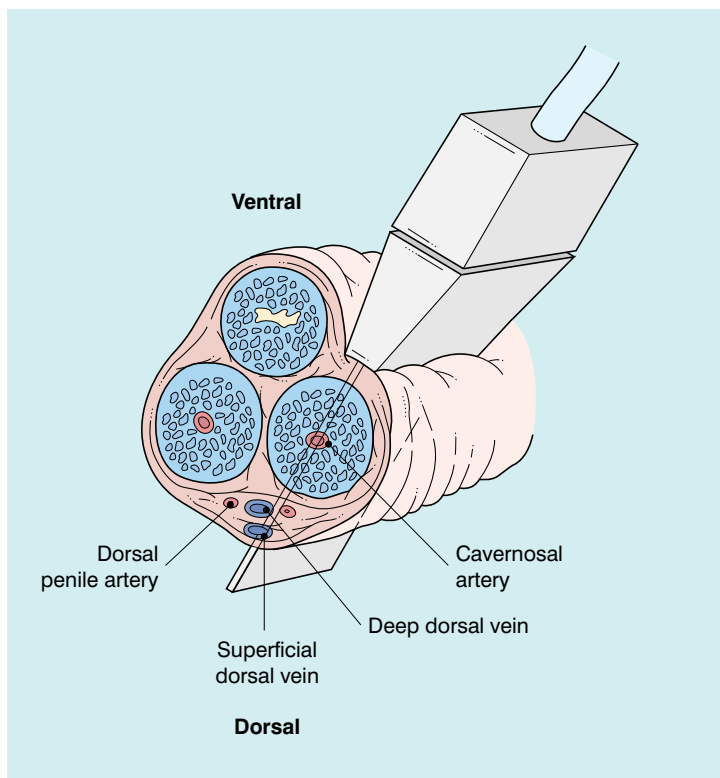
Ultrasound technique. A linear transducer is placed in a longitudinal plane along the ventral surface of the penis. Since the cavernosal arteries run parallel to the transducer, electronic steering of the Doppler beam is necessary to interrogate at an appropriate angle.
